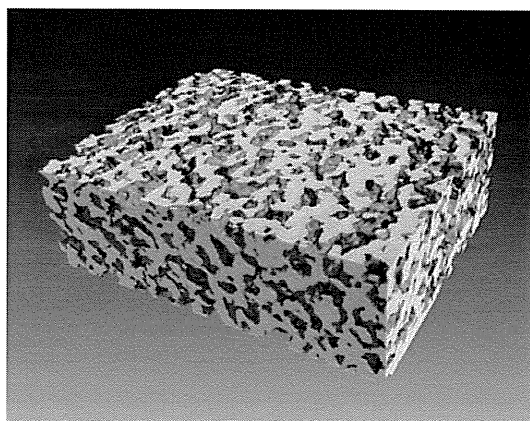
Micro-computed tomography image showing well-connected internal porous structures
